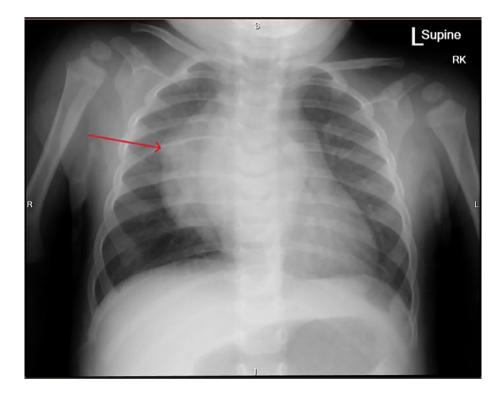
Chest x-ray (AP view) shows dense structure in the right hemithorax (red arrow).
